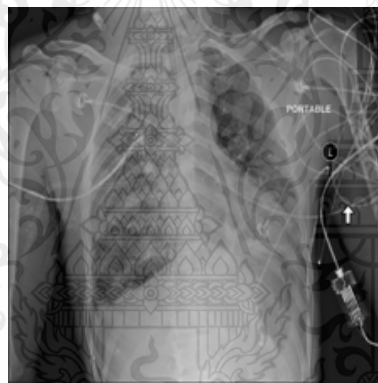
Example of Consolidation chest X-Ray image (Wang, Yifan Peng, Le Lu, Zhiyong Lu, & Ronald M. Summers, 2018)
